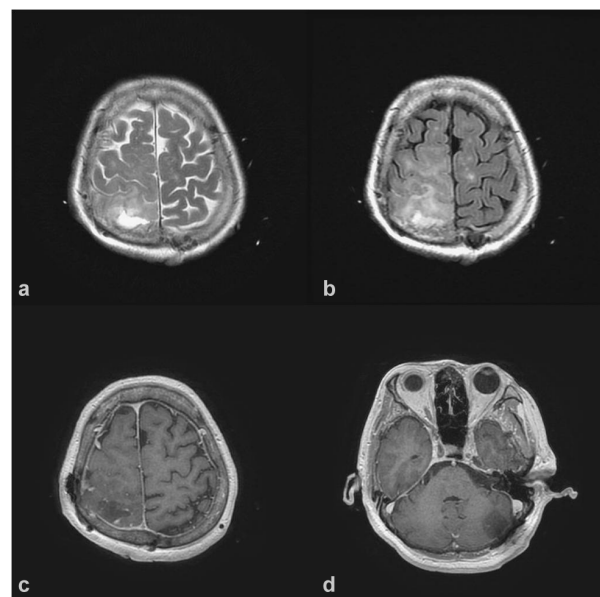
Postoperative brain magnetic resonance imaging (MRI). Axial T2-weighted image (T2WI) (a) fluid-attenuated inversion recovery (FLAIR) (b) and axial T1-weighted image (T1WI) post gadolinium injection (c) showing a good resection of the right superior parietal lobule lesion with some postoperative change. Axial T1WI post gadolinium injection (d) revealing the total resection of the left cerebellar tumor without residual tumor.
